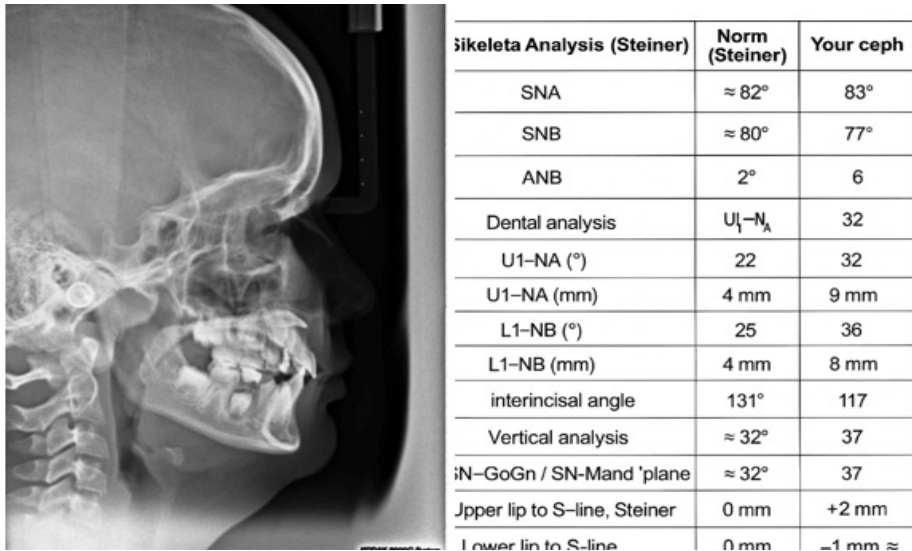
Lateral radiograph and cephalometric analysis
